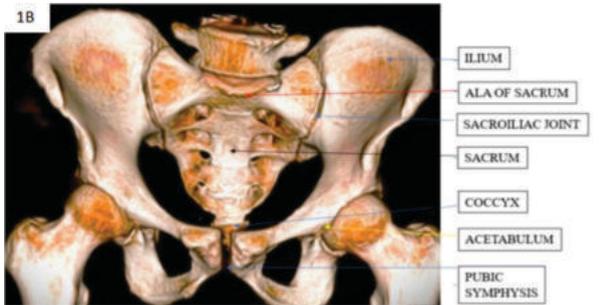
CT 3D bone reconstruction image demonstrating normal anatomy of the pelvic bone.
